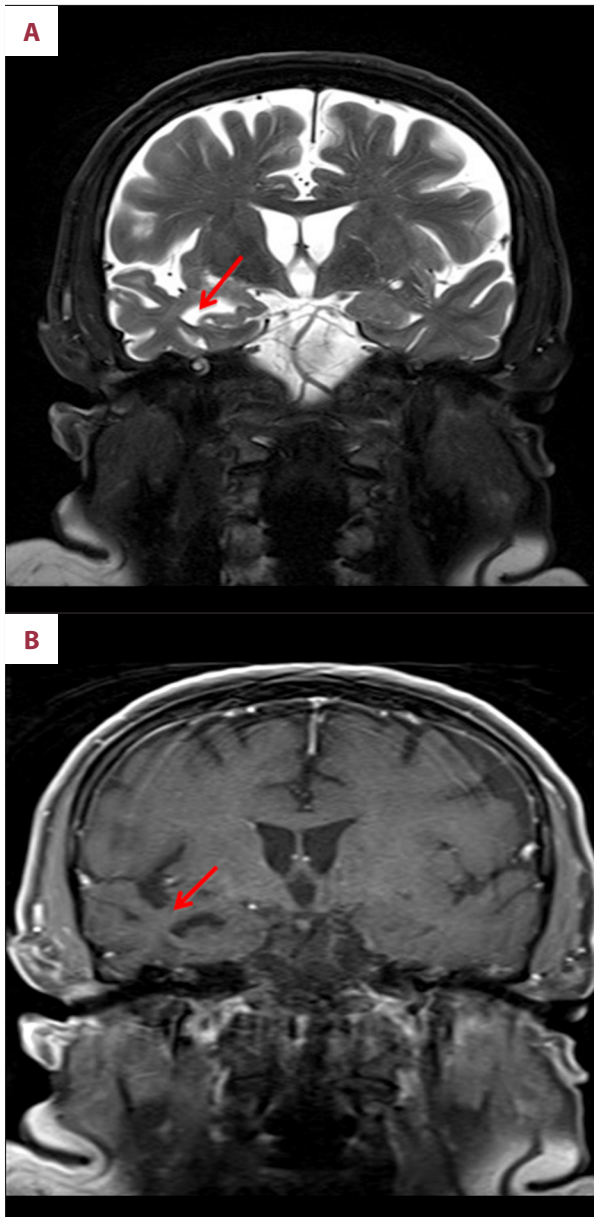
Brain MRI 4 months, post treatment. (A) MRI, T2 weighted image, coronal window, showing residual low signal intensity, gliosis and atrophy on the right temporal lobe. (B) MRI, T1 coronal window post contrast, showing right temporal low signal intensity, gliosis and atrophy with no contrast enhancement.
